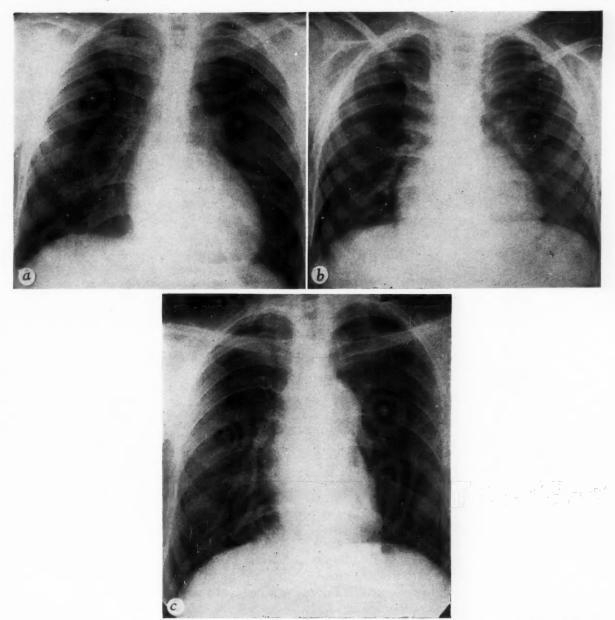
to C. Postero-anterior roentgenograms of chest in Cases I, III and x. The presence of cardiac enlargement, the prominence of the pulmonary artery and the appearance of pulmonary vascular markings are given in Table I.
